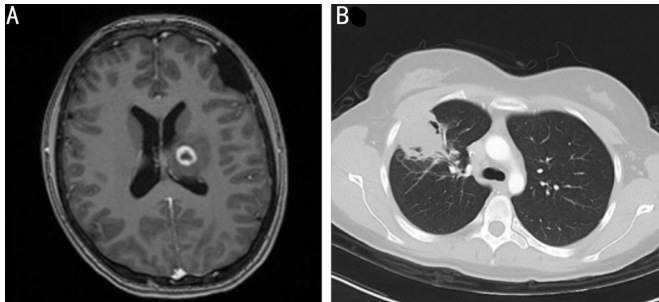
Cross sectional imaging A: Axial T1 MRI of the brain demonstrating a ring enhancing lesion with local mass effect in the left thalamus; B: Axial CT of the chest demonstrating a cavitation lesion of the right middle lobe.
